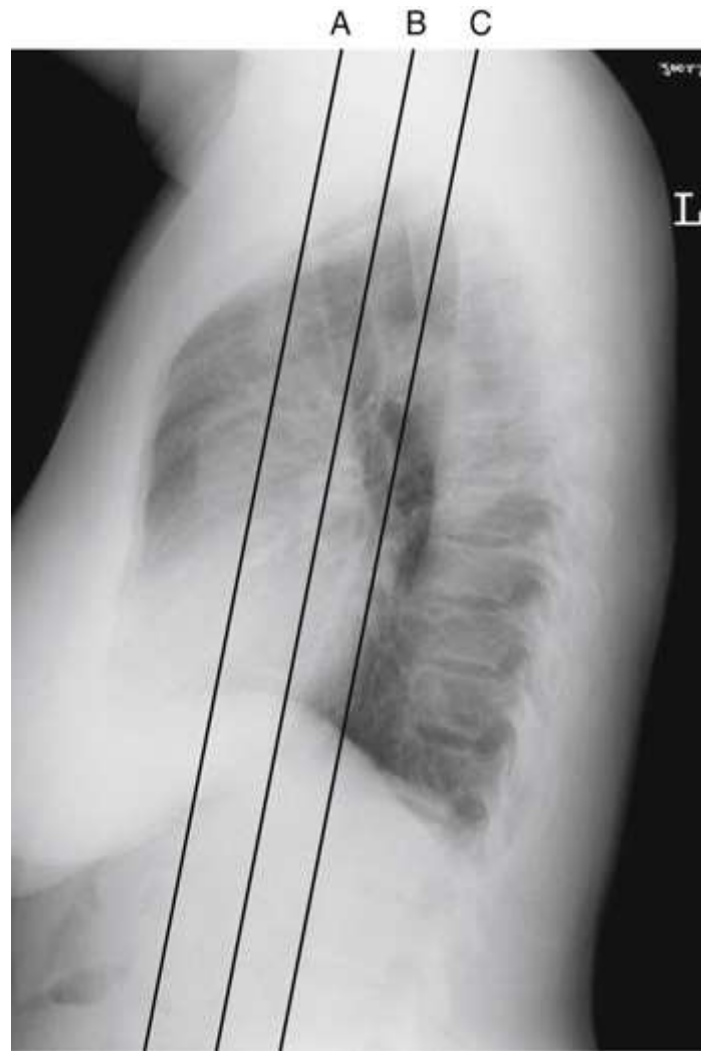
Lateral chest x-ray representing levels of coronal sections through thorax.
